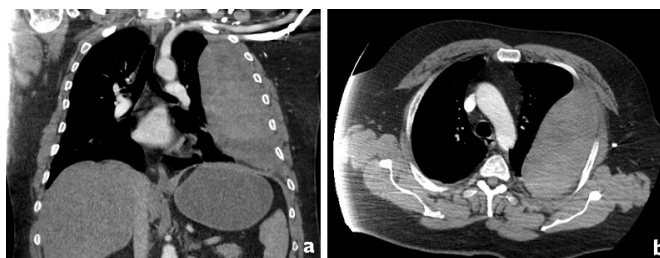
A) CT scan of the chest (coronal view) from outside hospital at re-presentation noting a large extrapleural hematoma and a rightward shift of the mediastinal structures. B) CT scan of the chest (axial view)
